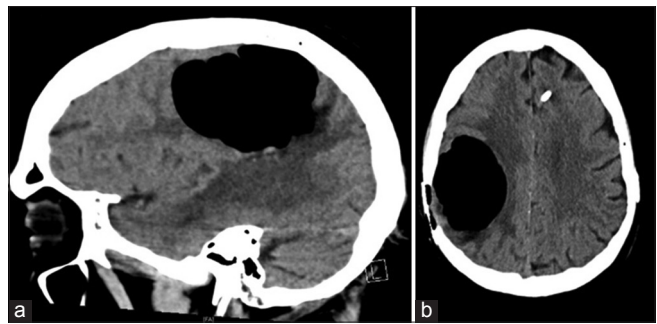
Sagittal (a) and axial (b) sections of computed tomography scan demonstrating pneumocephalus in the index patient
